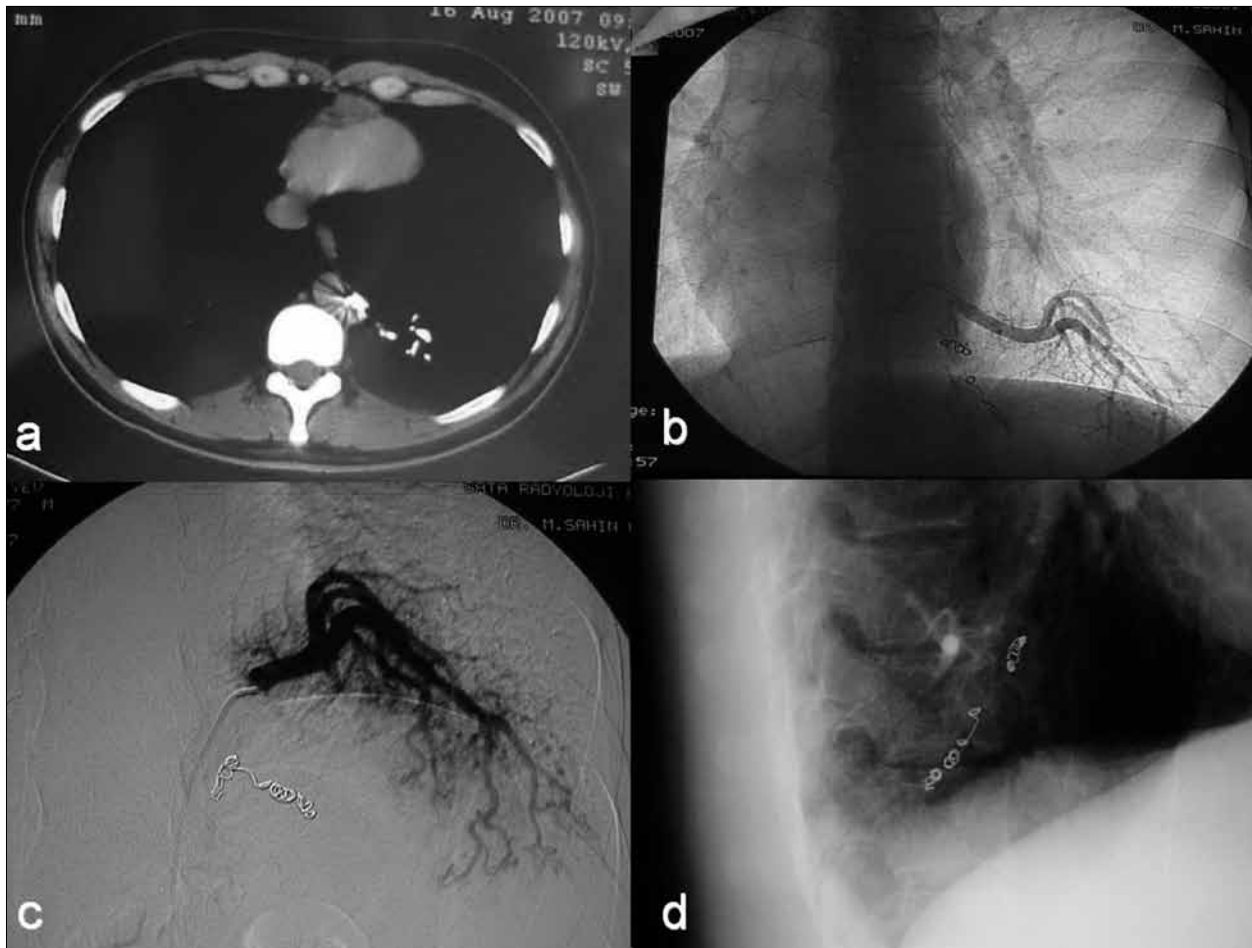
Axial plain of CT of the thorax reveal a feeding vessel of the sequestration arising from the thoracic aorta (a). Aortography shows the feeding vessels and coil therapeutic embolization is performed (b, c). Lateral chest roentgenogram shows the coils which were used for therapeutic embolization 4-month earlier to treat the hemoptysis
